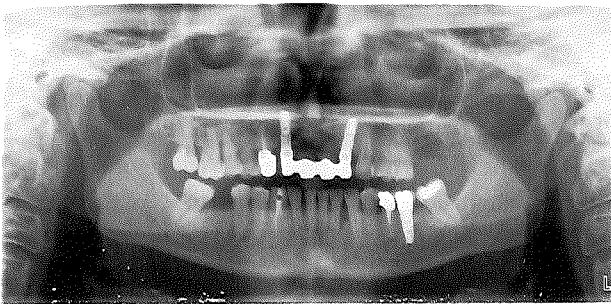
X-ray after 1 year.
